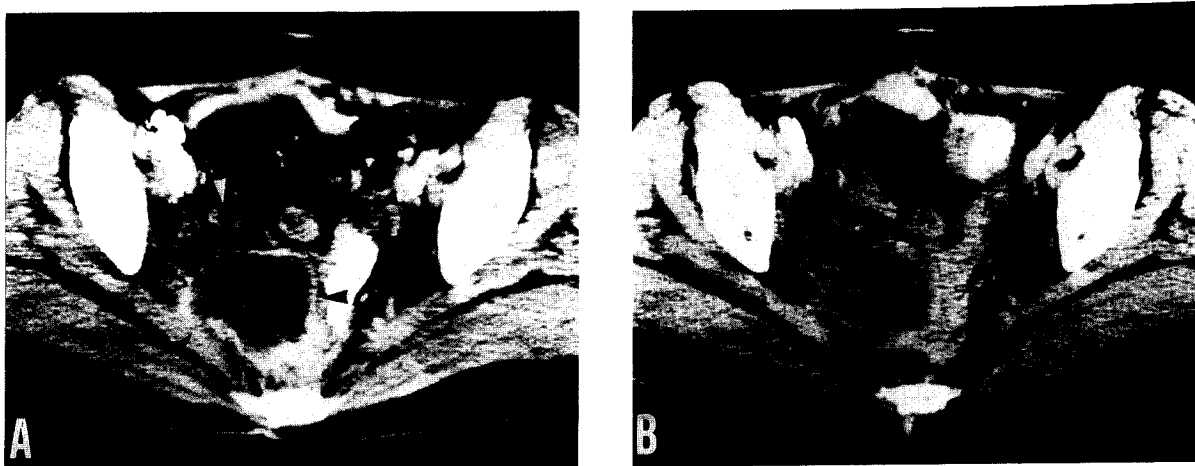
CT of case No. 4. A; Before treatment. Arrow heads indicate extensive low density areas within the tumor and a thin circumferential layer of tumor parenchyma of soft tissue density. B; After treatment. Tumor parenchyma has thinned.
